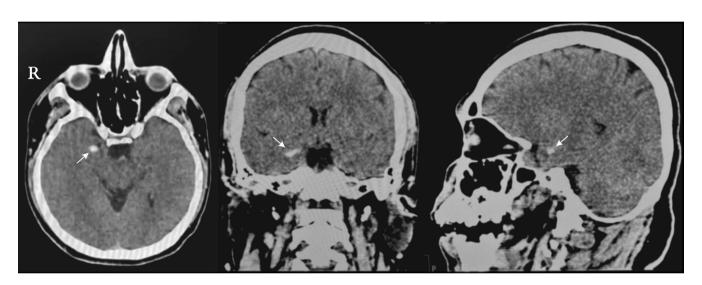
CT without contrast displays parenchymal cysticercosis with a calcified granuloma in the right mesial temporal region (arrows in axial, coronal, and sagittal views).
